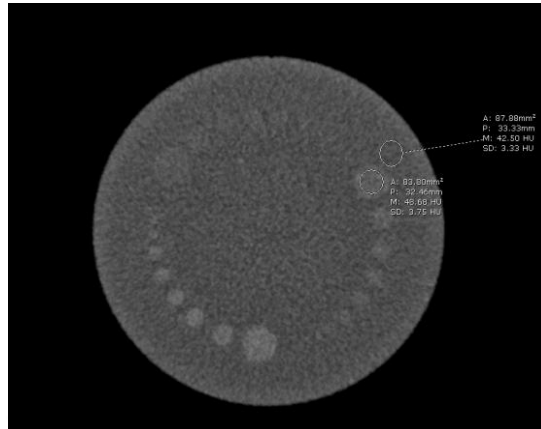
5 Measurement the CT number of low contrast object and background
